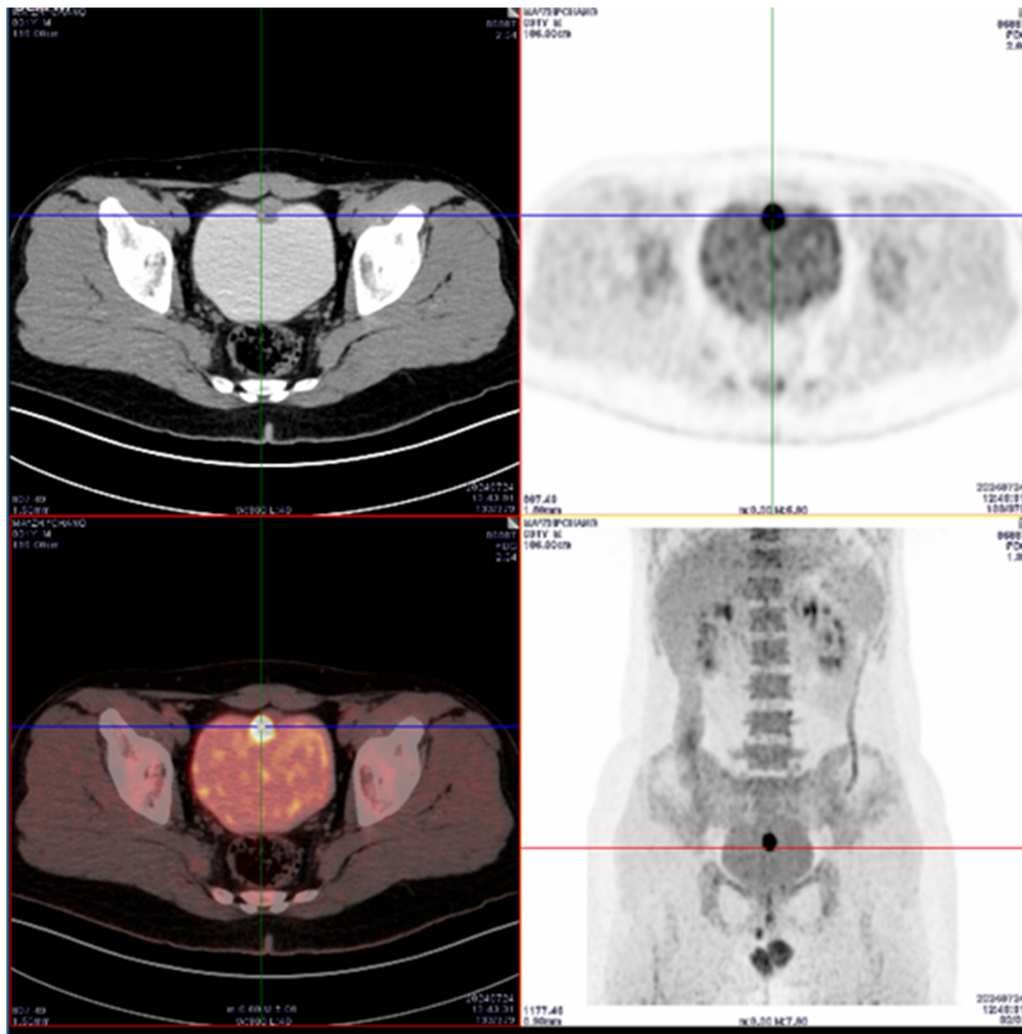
Preoperative ¹⁸F-FDG-PET/CT results showed a 1.9x1.8 cm hypermetabolic nodule at the bladder dome. Standardized Uptake Value maximum=20.4 on delayed imaging). No regional lymphadenopathy or distant metastases were detected.
